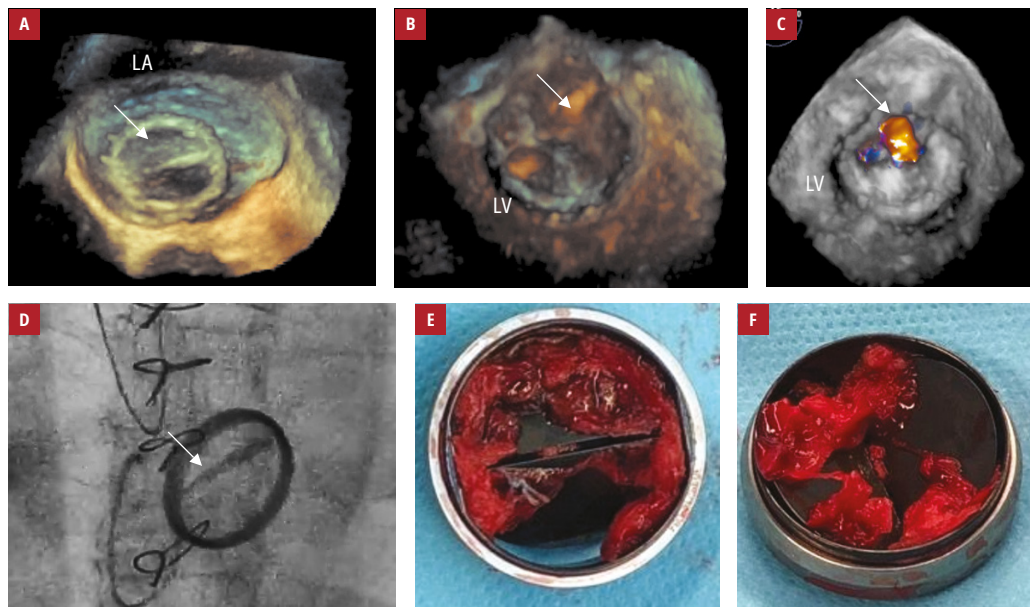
A – an immobilized mitral prosthesis disc (arrow); 3-dimensional transesophageal echocardiography (3D TEE), left atrial view; B – pathological masses on the valve prosthesis (arrow); 3D TEE, left ventricular view; C – turbulent mitral valve inflow (arrow); color Doppler, 3D TEE, left ventricular view; D – a blocked mitral prosthesis disc visible on fluoroscopy (arrow); E – an explanted mitral valve prosthesis with thrombus (ventricular surface); F – an explanted mitral valve prosthesis with thrombus and pannus (atrial surface)
